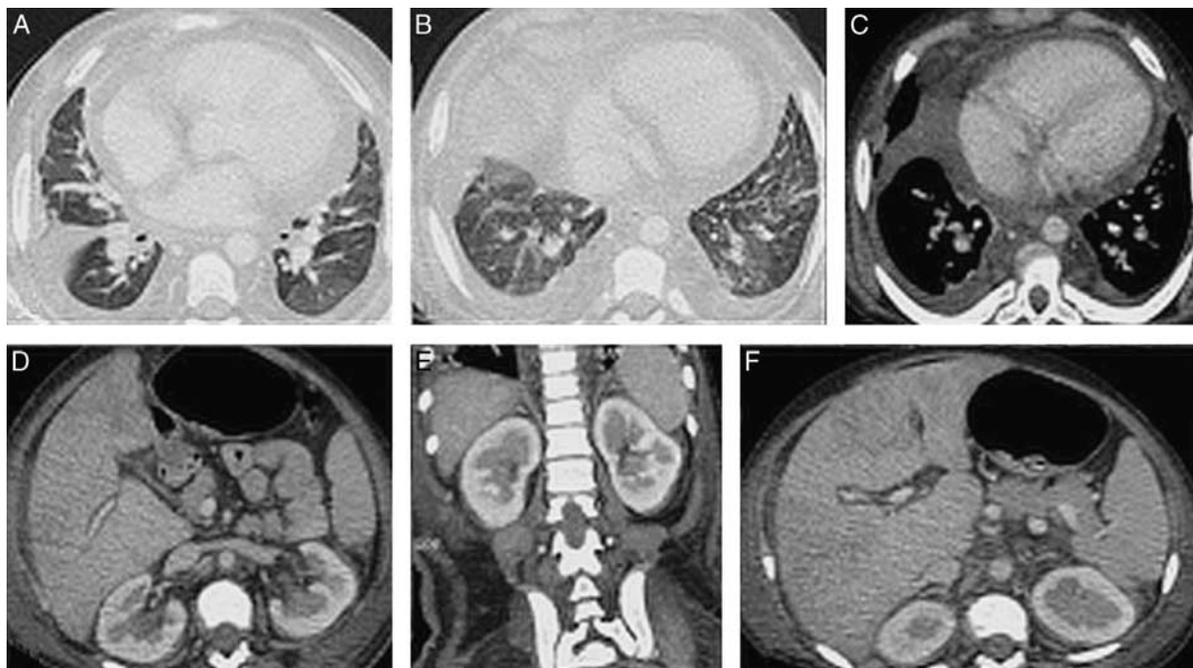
Axial contrast-enhanced chest computerized tomography (CT) scan through lung bases shows diffuse smooth symmetric interlobular septal and fissural thickening (A), and diffuse multifocal patchy areas of ground-glass attenuation in bilateral lung bases (B). Mediastinal windowing image shows pericardial and bilateral pleural effusions with thickening (C). Axial and coronal maximum intensity projection reconstruction-enhanced abdomen CT images shows enhancing irregular soft tissue infiltration of the perirenal spaces (hairy kidney appearance) bilaterally (D, E). Abdominal CT image through the liver shows periportal low attenuation (F).
